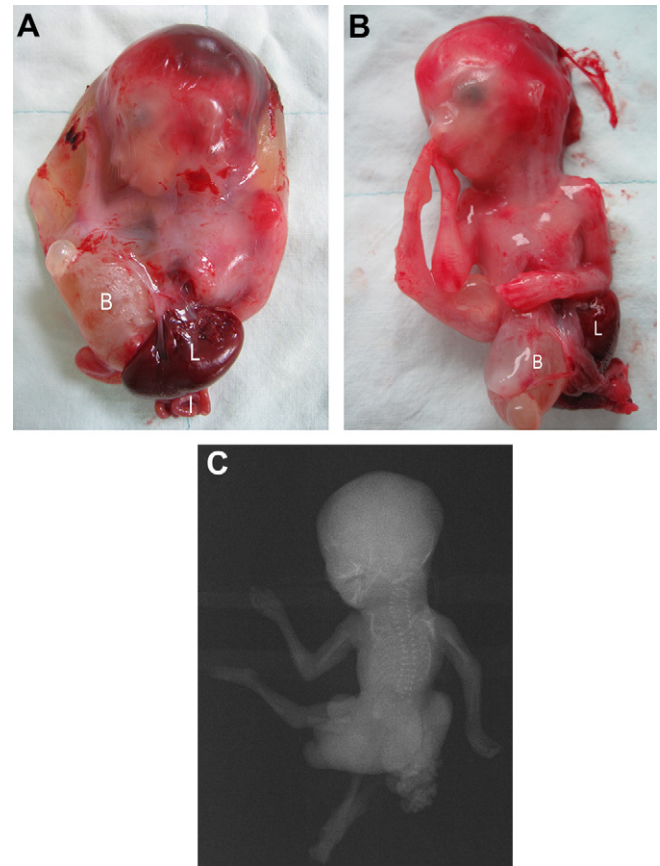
(A) A fetus with limb–body wall complex wrapped up in the amnion with extracorporeal internal organs. (B) Extracorporeal giant urinary bladder, intestines, and liver; a deficiency of left lower limb; and hyperextension of right lower limb. (C) X-ray of the fetus. B = bladder; I = intestines; L = liver.
